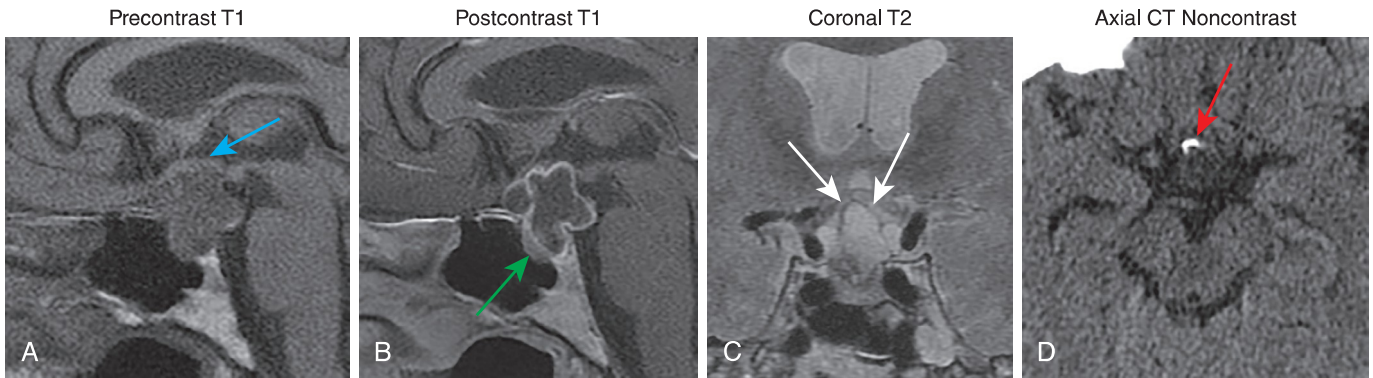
Craniopharyngioma. (A) Sagittal T1 precontrast magnetic resonance imaging (MRI) demonstrates a T1 hypointense lobulated sellar and suprasellar lesion elevating the optic chiasm (*blue arrow*). (B) Sagittal T1 postcontrast MRI demonstrates smooth peripheral enhancement of the predominantly cystic lesion. (Note the normally enhancing pituitary gland along the anterior floor of the sella [*green arrow*].) (C) Coronal T2 MRI demonstrates a predominantly hyperintense cystic sellar and suprasellar lesion (*white arrows*). (D) Axial noncontrast computed tomography confirmed the presence of peripheral calcification (*red arrow*), most typical of an adamantinomatous type craniopharyngioma.
